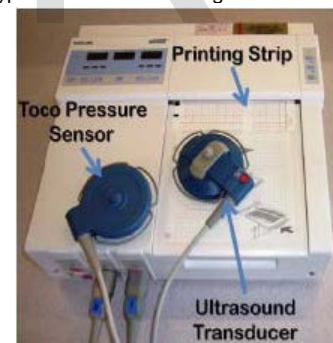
A standard fetal monitoring device including toco pressure sensor, ultrasound transducer and central/printing unit.
